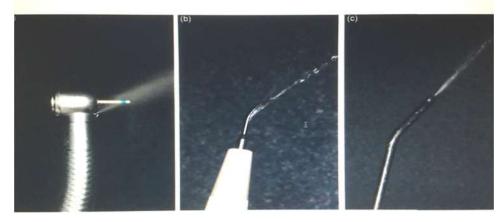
Aerosols generated by dental high-speed handpoece (a), ultrasonic scaler (b), and air-water syringe (c)
